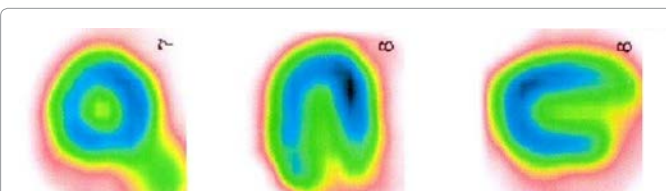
The rest myocardial perfusion scintigraphy made in two months after incident, without any significant perfusion defects.
